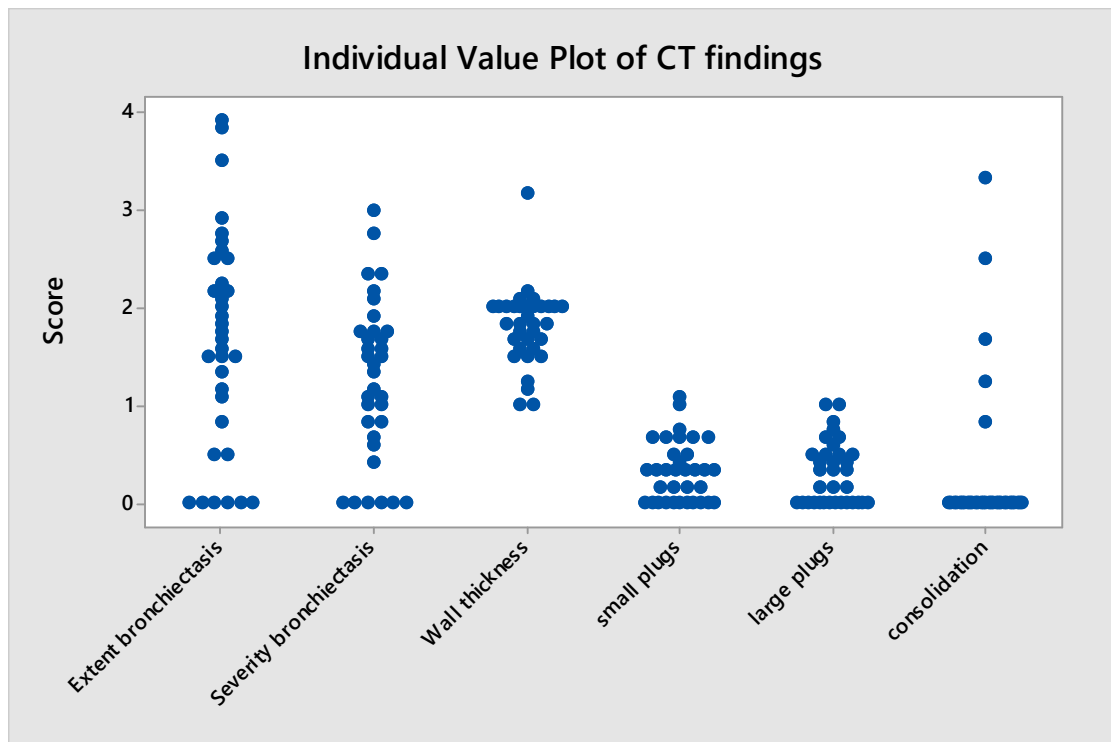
CT scores at visit 1
